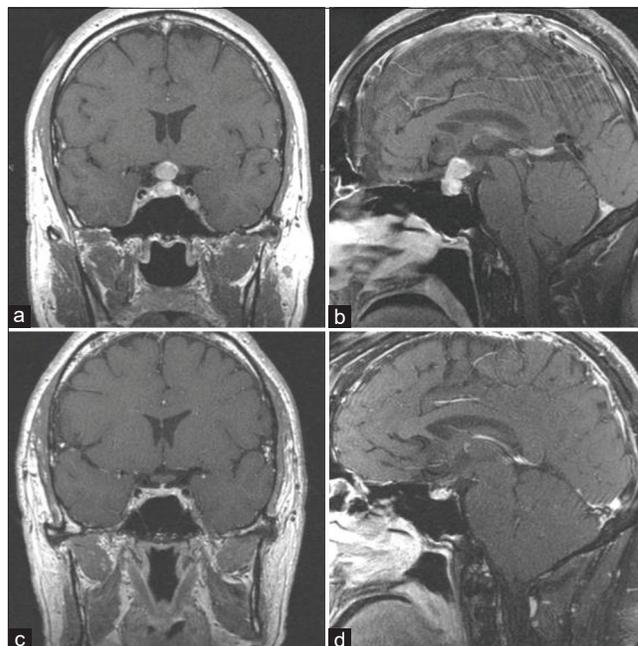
(a) Pretreatment coronal and (b) sagittal-contrasted magnetic resonance imaging (MRI) demonstrating sellar and suprasellar enhancing lesion with compression of the optic chiasm. (c) Posttreatment coronal and (d) sagittal-contrasted MRI demonstrating complete resolution of pituitary lesion.
